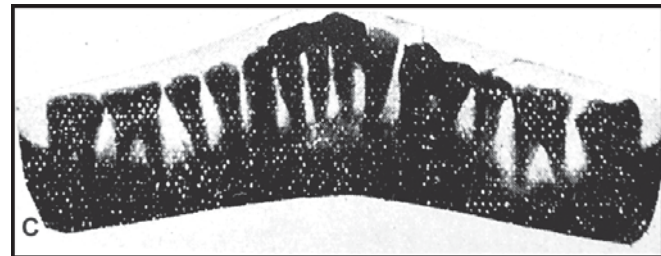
Mandibular radiograph taken by Numata's method
